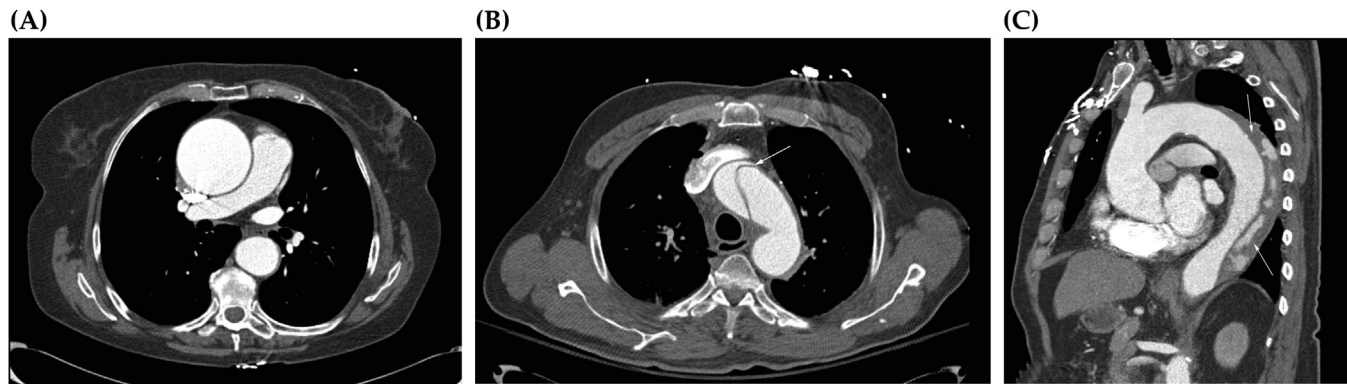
Computed tomography angiography of patients with GCA demonstrating 6.4 cm ascending aortic aneurysm (panel A – axial view), proximal thoracic aortic dissection (panel B – axial view) and type B dissection of thoracic aorta with false lumen (arrows) posteriorly (panel C – sagittal view). Adapted from the personal collection of Dr. Kenneth Warrington, Division of Rheumatology, Mayo Clinic, Rochester, MN, USA.
